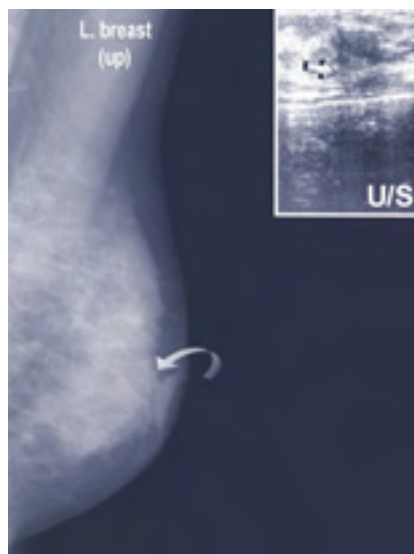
Conventional X-ray mammography (main frame) and breast ultrasonography (embedded frame). Parenchymal architectural distortion behind the nipple, with skin thickening and retraction (curved arrow), corresponding to an irregular, ill-defined, heterogeneous, hypoechoic mass (transparent arrow), with acoustic shadowing and a hyperechoic rim
